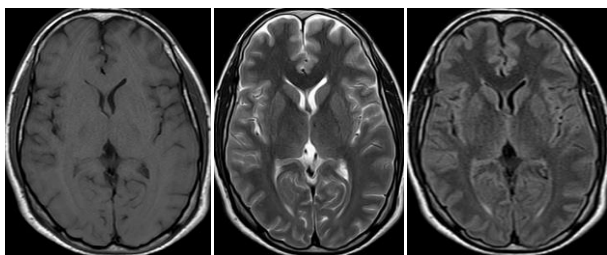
MRI brain (T1w, T2w and flair sequences) shows normal imaging.
